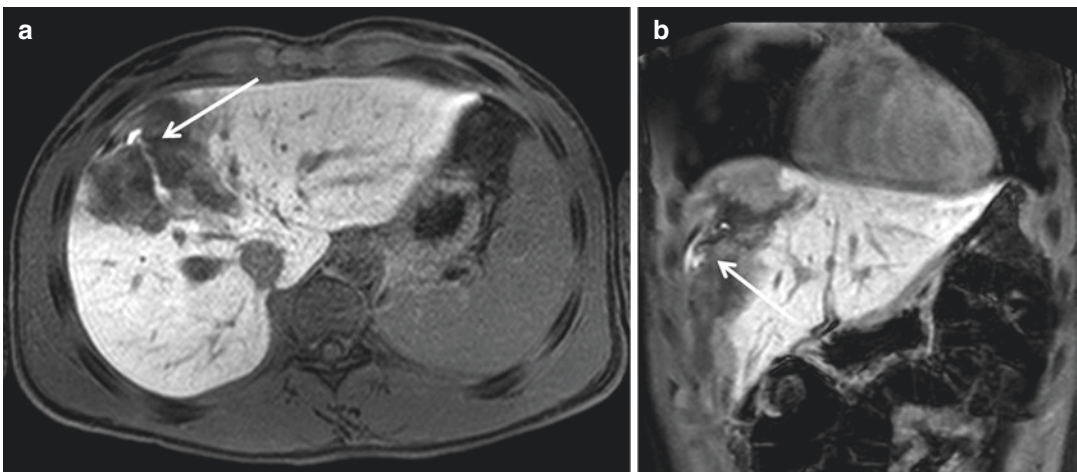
Coleperitoneum is a bile effusion into the peritoneal cavity, diagnosed by MRI with specific liver contrast media in the hepatobiliary phase (T1 W-fat sat). Axial scan (a) and coronal scan (b)
